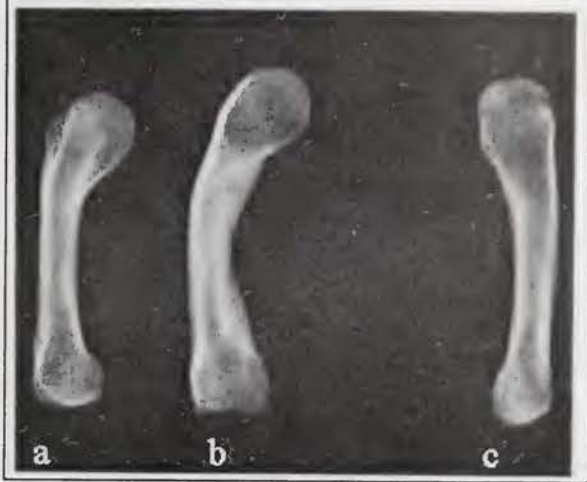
(lower). Voëlvlei 2 – radiographs of metatarsals: a) left metacarpal 5, b) left metacarpal 4, c) right metacarpal 5.
